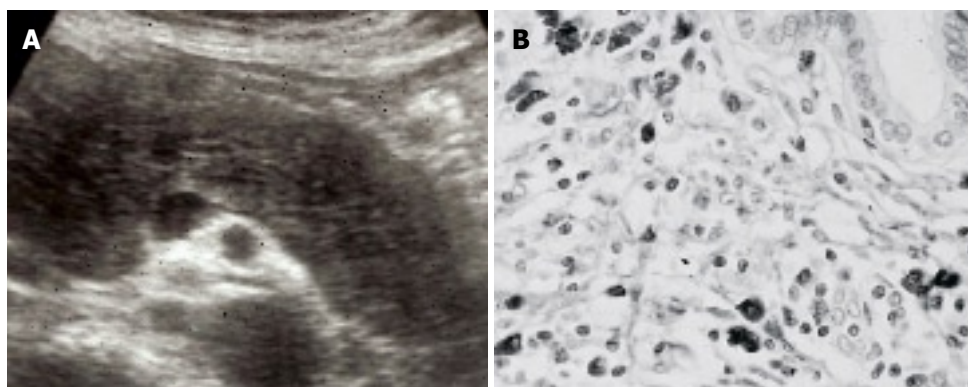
AIP. (A) Diffuse hypoechoic enlargement of the pancreas on ultrasonography; (B) Dense infiltration of IgG4-positive plasma cells in the pancreas.
